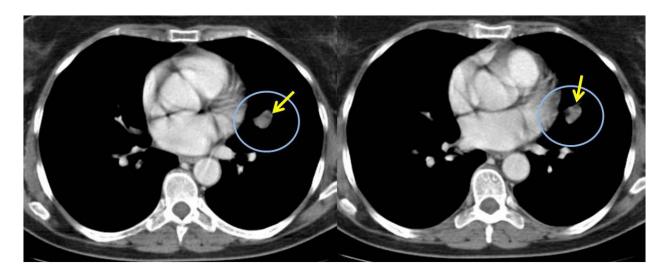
Parenchymal hamartoma. CT scan shows a solitary pulmonary nodule containing a focus of fat attenuation.
